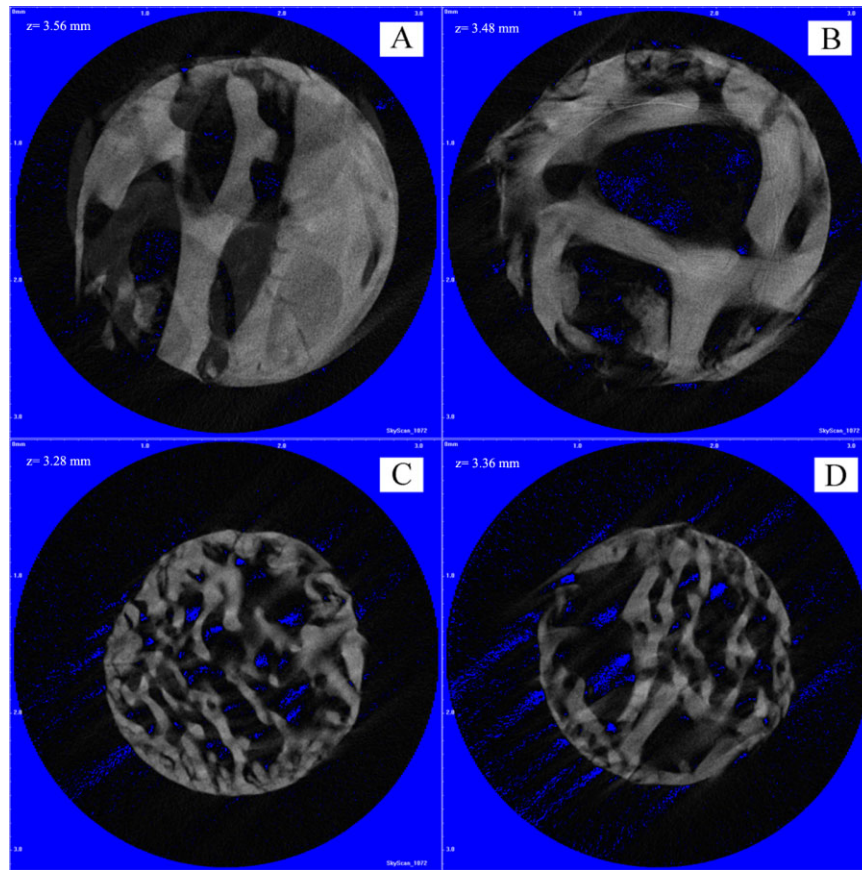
Three-dimensional images from stacks of two-dimensional micro-computed tomography images. (A) Reconstruction of maxillary bone of density D1 ($z = 3.56$ mm). (B) Reconstruction of maxillary bone of density D2 ($z = 3.48$ mm). (C) Reconstruction of maxillary bone of density D3 ($z = 3.28$ mm). (D) Reconstruction of maxillary bone of density D4 ($z = 3.36$ mm).
